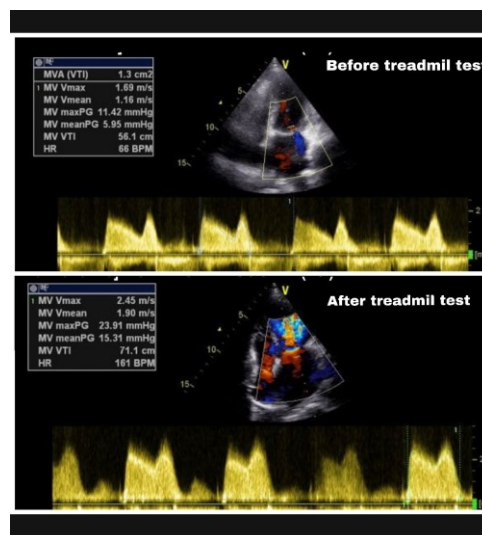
Doppler evaluation pre and post exercise stress echo.
